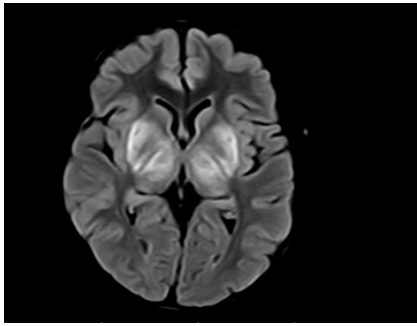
MRI showing, Axial FLAIR at the level of the basal ganglia demonstrates symmetric hyperintensity of the putamina and thalami, - favor Wilson disease.
